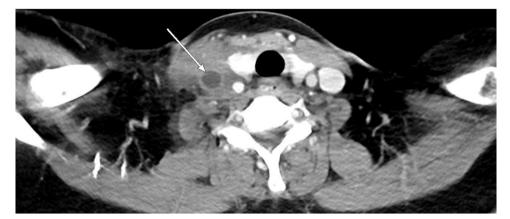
Axial view of CT neck with and without IV contrast. White arrow showing completely occluded right internal jugular vein, secondary to thrombosis.
